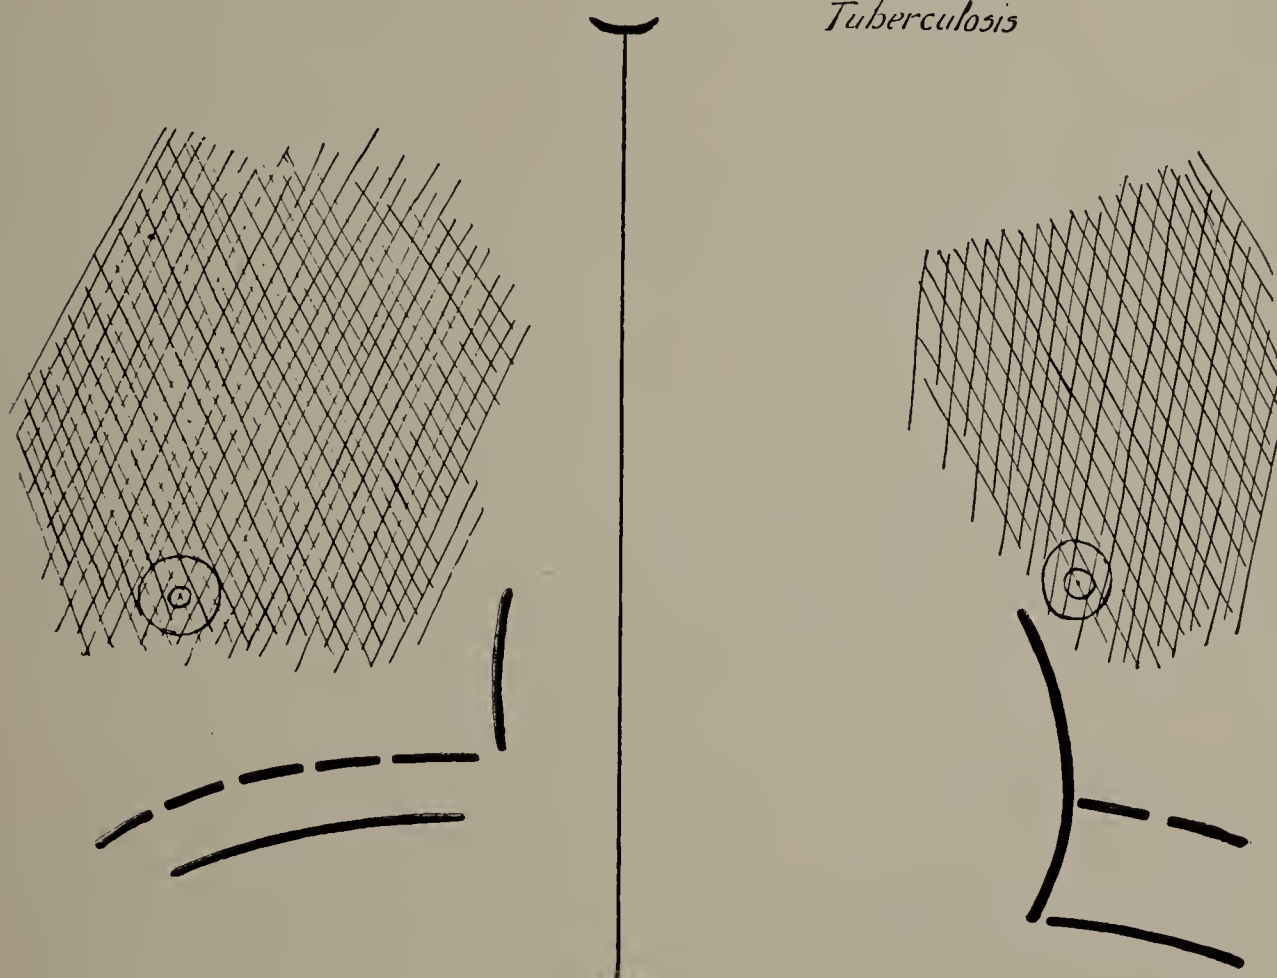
John H. January 3, 1900. Tuberculosis. X-ray examination with screen showed darkened lungs, but apices and bases less affected than physical signs indicated. Autopsy confirmed X-ray examination. Excursion of diaphragm shortened on both sides. See Fig. 80 for half-tone of a radiograph of lung. (One-third life size.)
